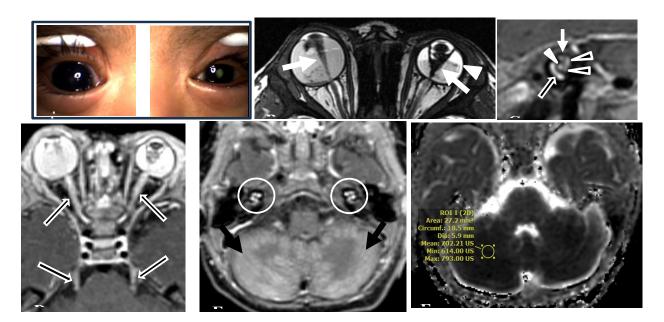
CASE 2. MRI examination with and without IV gadolinium in five-month-old male presenting with bilateral leukocoria. Clinical photograph of the eyes (A) best demonstrates leukocoria in the left eye. Axial bSSFP image (B) demonstrates bilateral funnel retinal detachments (white arrows) with hemorrhagic exudates, debris, and fluid-fluid levels (white arrowhead). There is mild buphthalmos of the right eye. Sagittal oblique post-gadolinium T1W fat saturation image (C) of the right internal auditory canal demonstrates enhancement of the facial nerve (white arrow), cochlear nerve (arrowhead), and vestibular nerves (black arrowheads). The cochlear basilar turn is enhancing (open arrow). These findings were also seen in the left internal auditory canal (not shown). Axial post-gadolinium T1W fat saturation images (D and E) show avid enhancement of the optic nerves and cisternal trigeminal nerves (open arrows in D) and avid enhancement of the cochlea (circles in E) and cerebellum (black arrows in E). ADC map (F) demonstrates diffusion restriction within the cerebellum.
